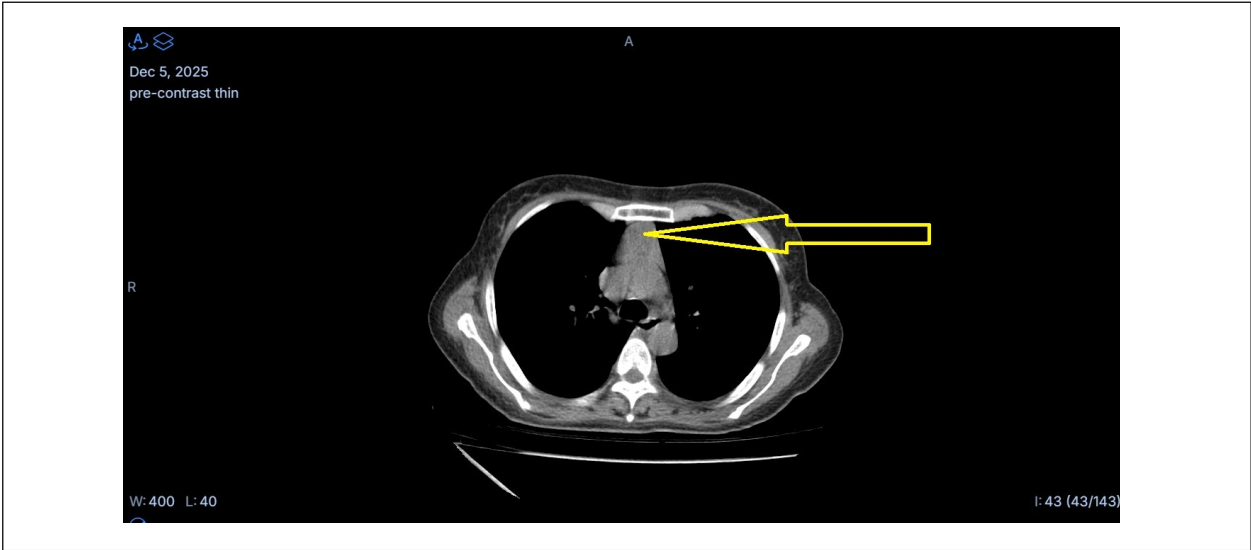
Axial non-contrast CT image showing an enlarged thymus
